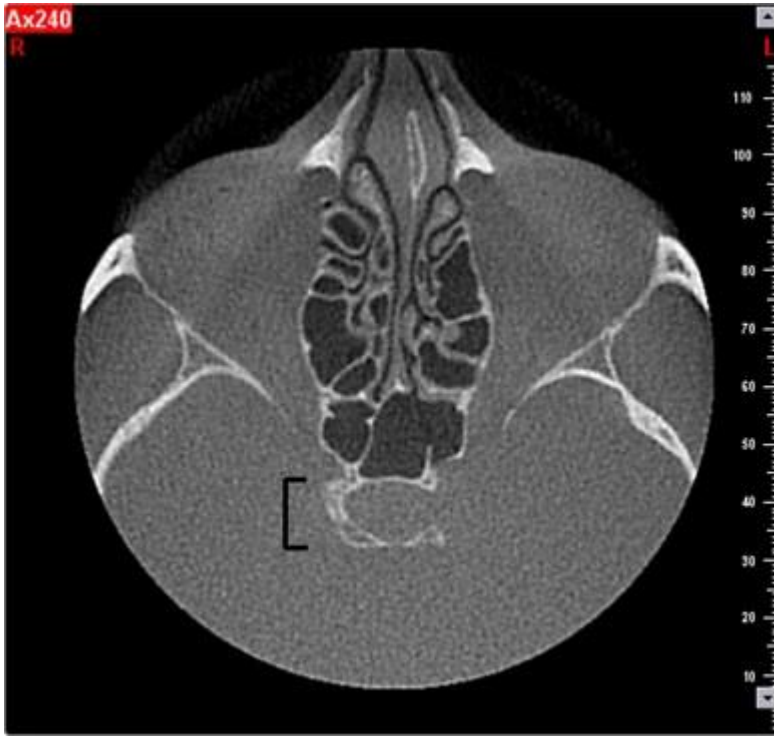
Axial cone beam computed tomography images of interclinoid ligament calcification (black symbol)
